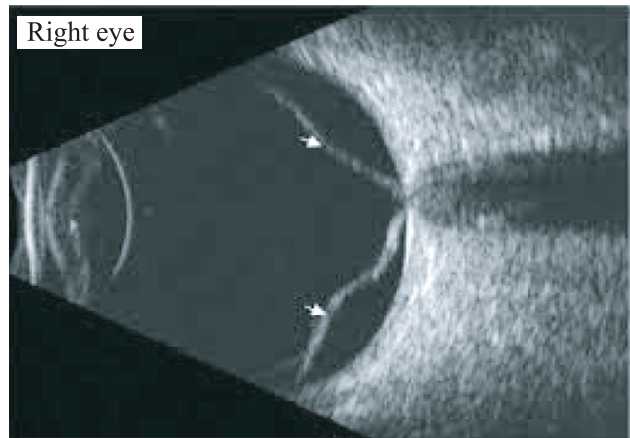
Ultrasonography B-scan showed high reflective membrane of retinal detachment in right eye.
